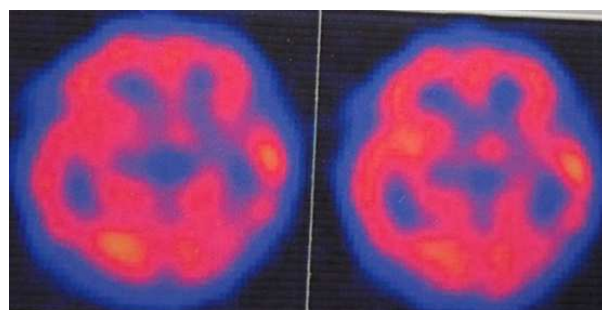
A, B SPECT after treatment: Cerebral perfusion restored to normal.
